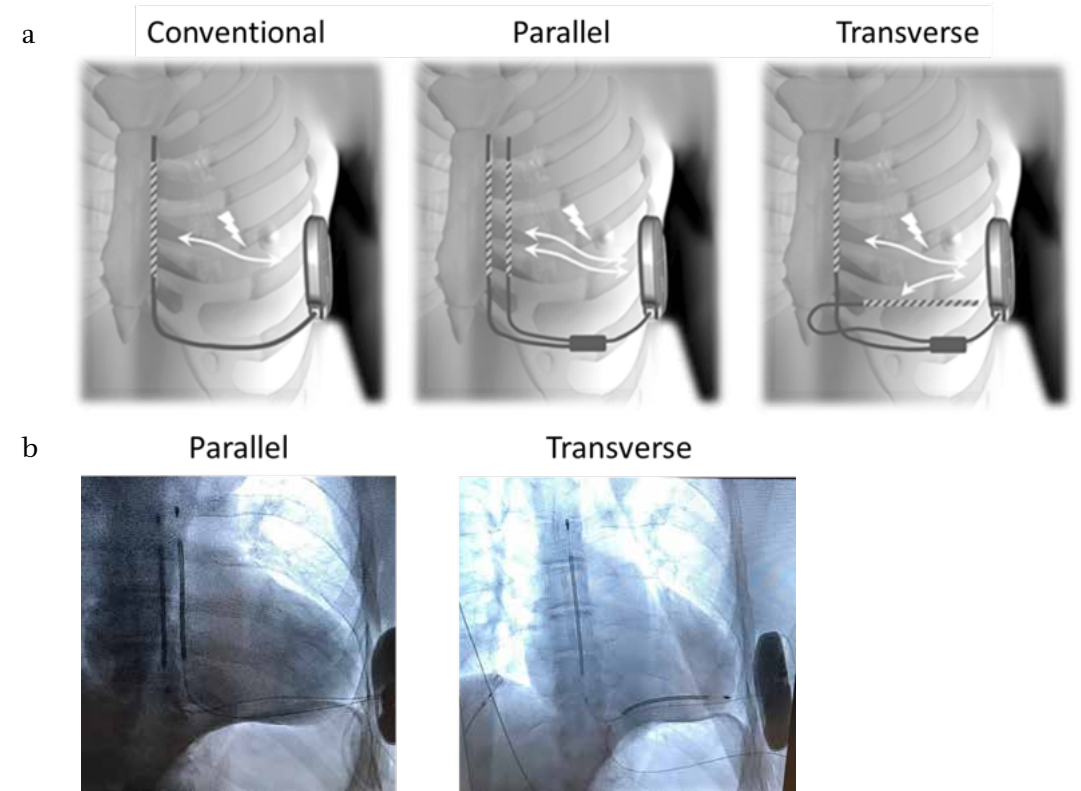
a) S-ICD Shock configurations. The conventional configuration was a single left parasternal electrode and S-ICD pulse generator, as used for all current S-ICD system implant. Parallel and transverse configurations added a second coil electrode for testing of new dual electrode configurations in this study. b) Fluorographic images of one tested patient showing parallel and transverse electrode locations.
